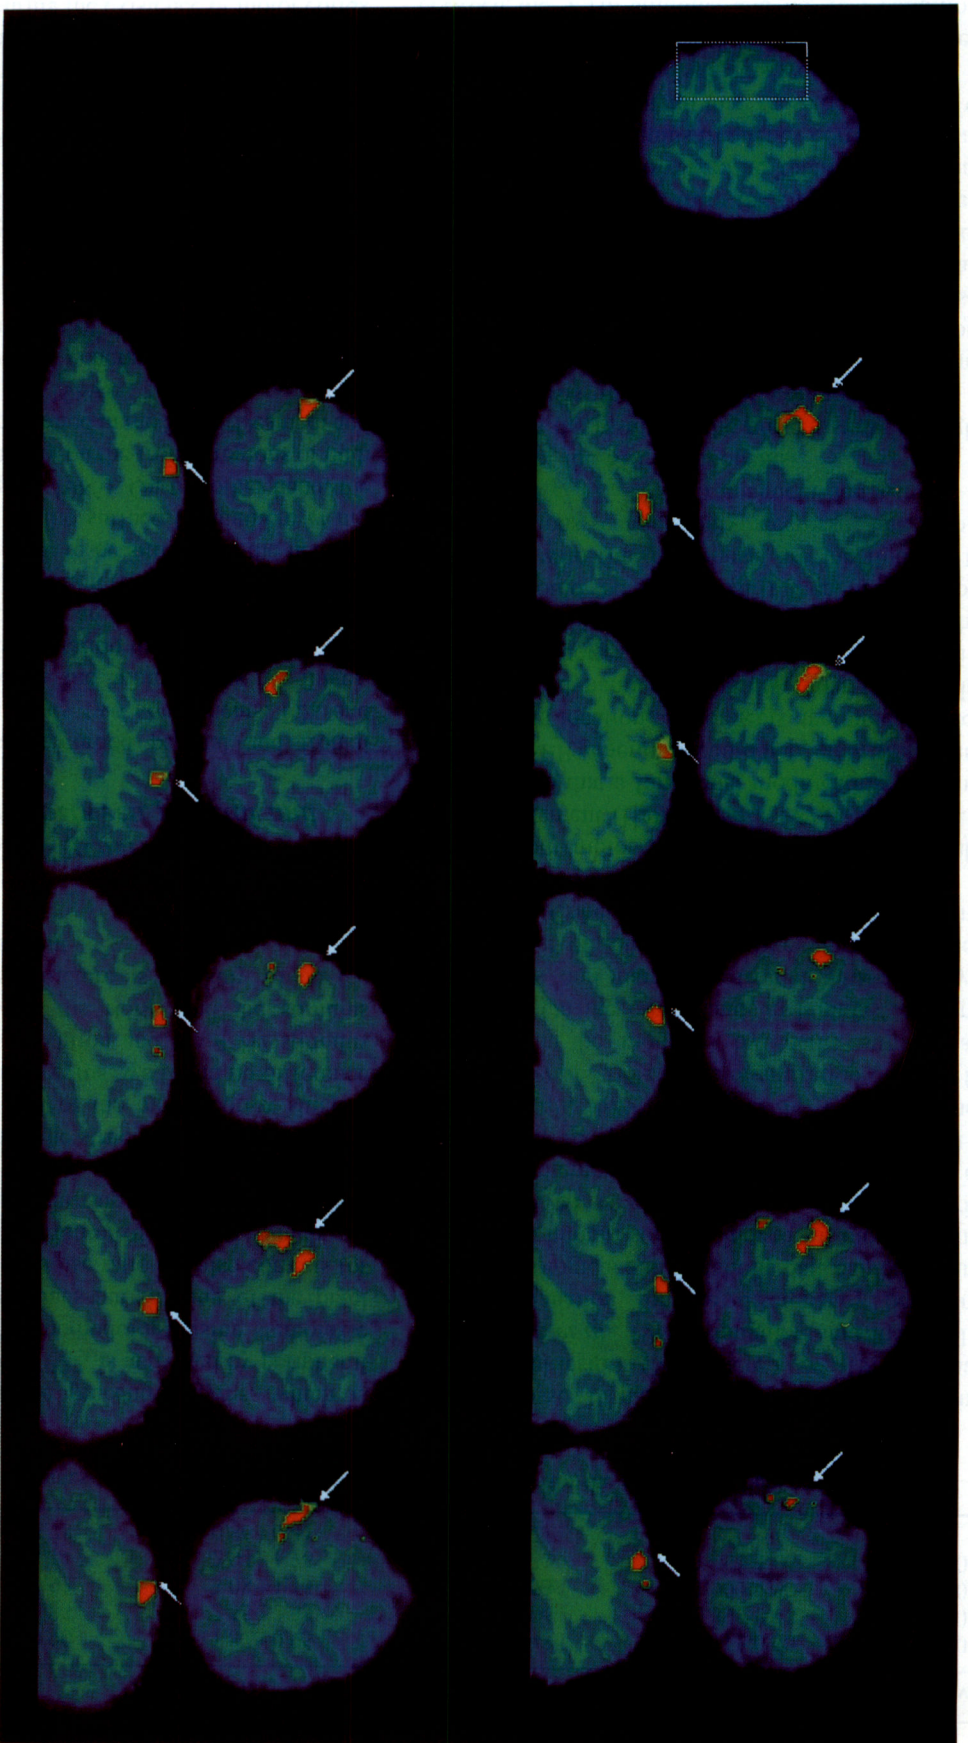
Superimposed transverse and sagittal MRI and PET images of the 10 subjects. To represent the results obtained by regions of interest analysis, a Gaussian kernel filter of 5×5 pixels was computed to the PET images and a subtraction between scans at the 4 Hz stimulus rate and the rest condition was obtained. Only rCBF above 46 ml/dl/min (2 SD below the mean calculated for motor cortex at rest in Table 2) was computed and the threshold set to 10% (mean percentage of the rCBF increase calculated on the area 3b) of the maximal pixel value obtained in the subtraction. The PET image subtraction was edited to leave only the region inside of the rectangle in the five planes used for regions of interest calculations. The images show a well-defined cluster of activity on the posterior bank of the central sulcus in most subjects, but no consistent cluster of activity on the crown of the precentral gyrus (arrows).
